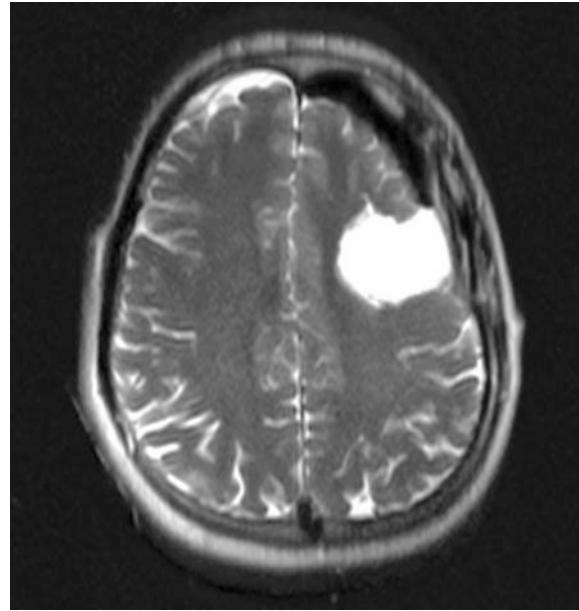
Postoperative axial half-Fourier acquisition single-shot turbo spin echo (HASTE) scan demonstrating the completion of the tumor resection. The entire tumor footprint has been removed radiographically and the resection cavity has been filled with cerebrospinal fluid. There is pneumocephalus still present over the left frontal lobe and the craniotomy has been closed
